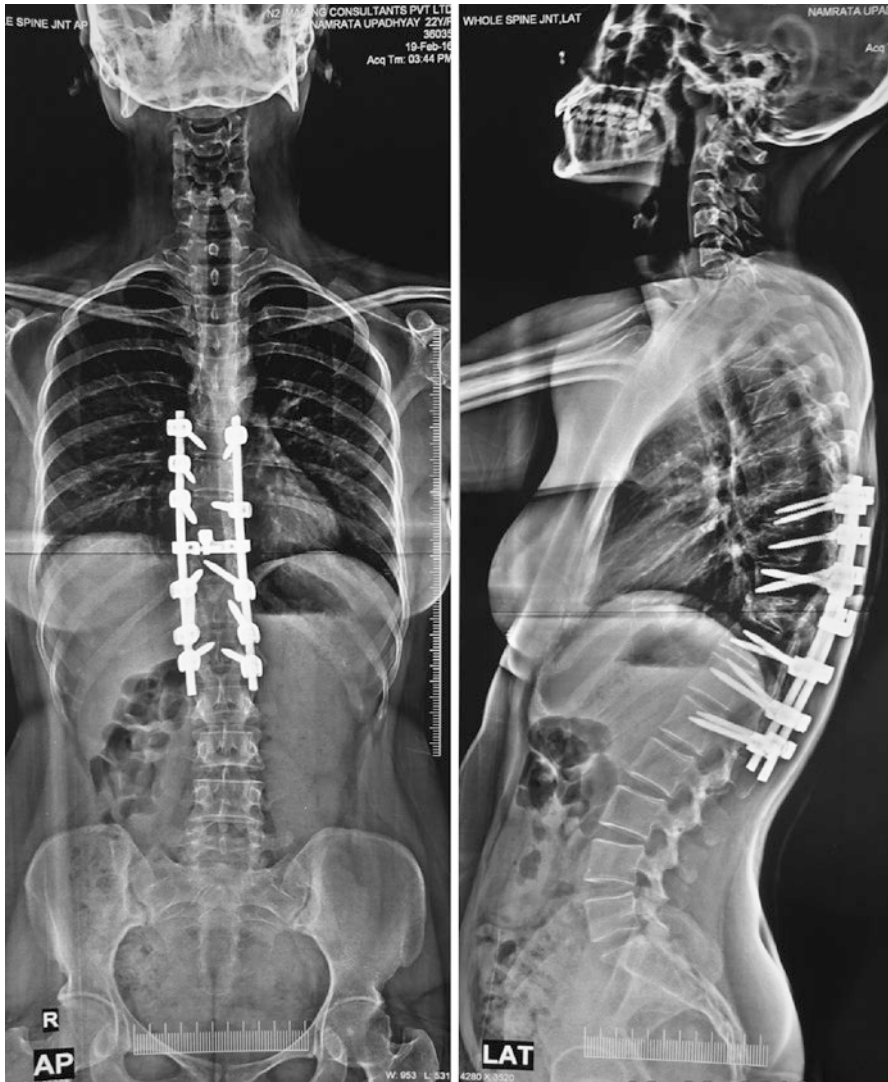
Post-operative radiograph of the patient following pedicle subtraction osteotomy with posterior instrumentation
